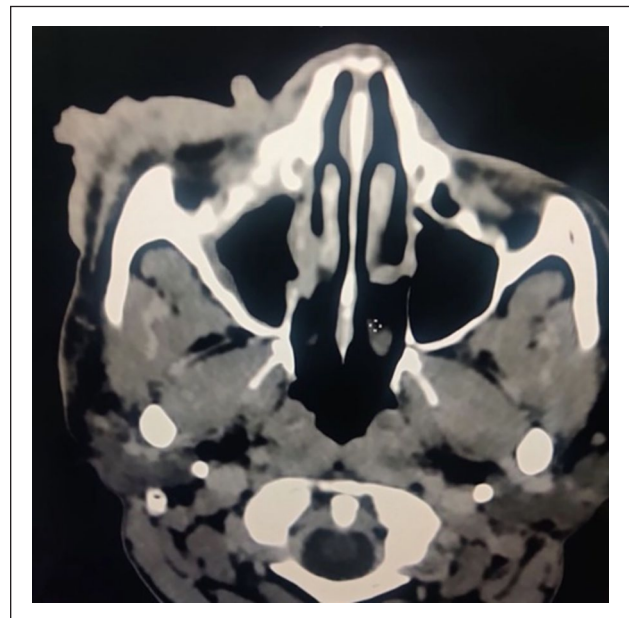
Post-contrast axial computed tomography images show enhancing nodular sheet-like mass on the right side of the face over the premaxillary and dorsum of the nose.
